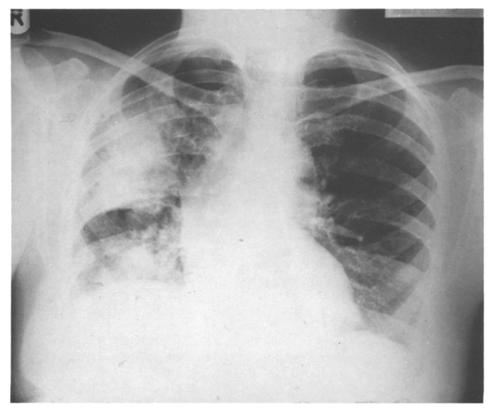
Chest radiograph showing opacities in the right upper and lower lobes
